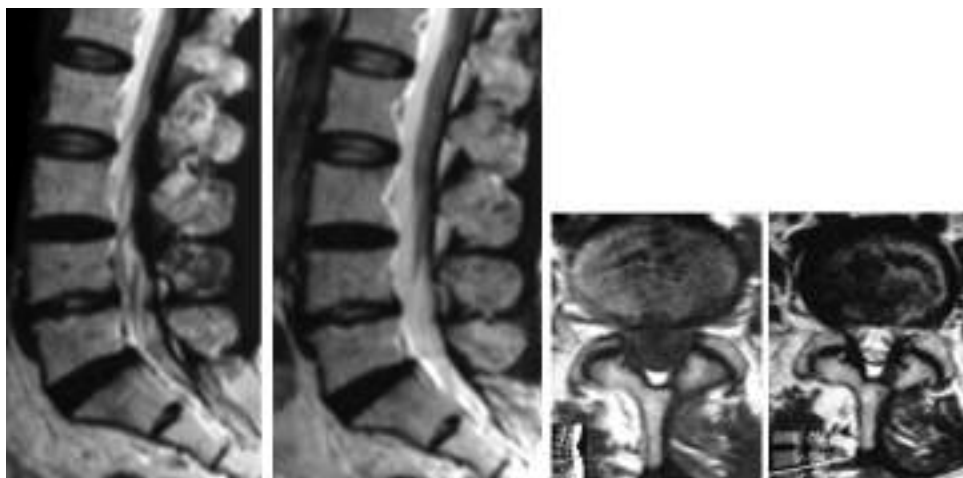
Postoperative MRI after excision of disc
